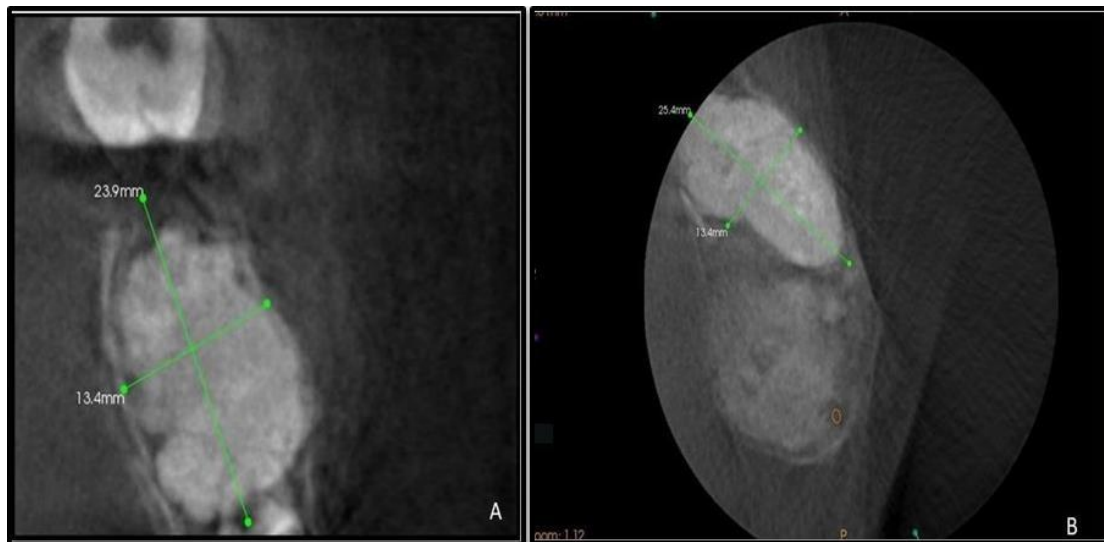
Coronal Section of CBCT showing measurement of the lesion in the cranio-caudal and medio-lateral planes. Figure-2B- Axial Section of CBCT showing measurement of the lesion in Antero-posterior and medio-lateral planes.
